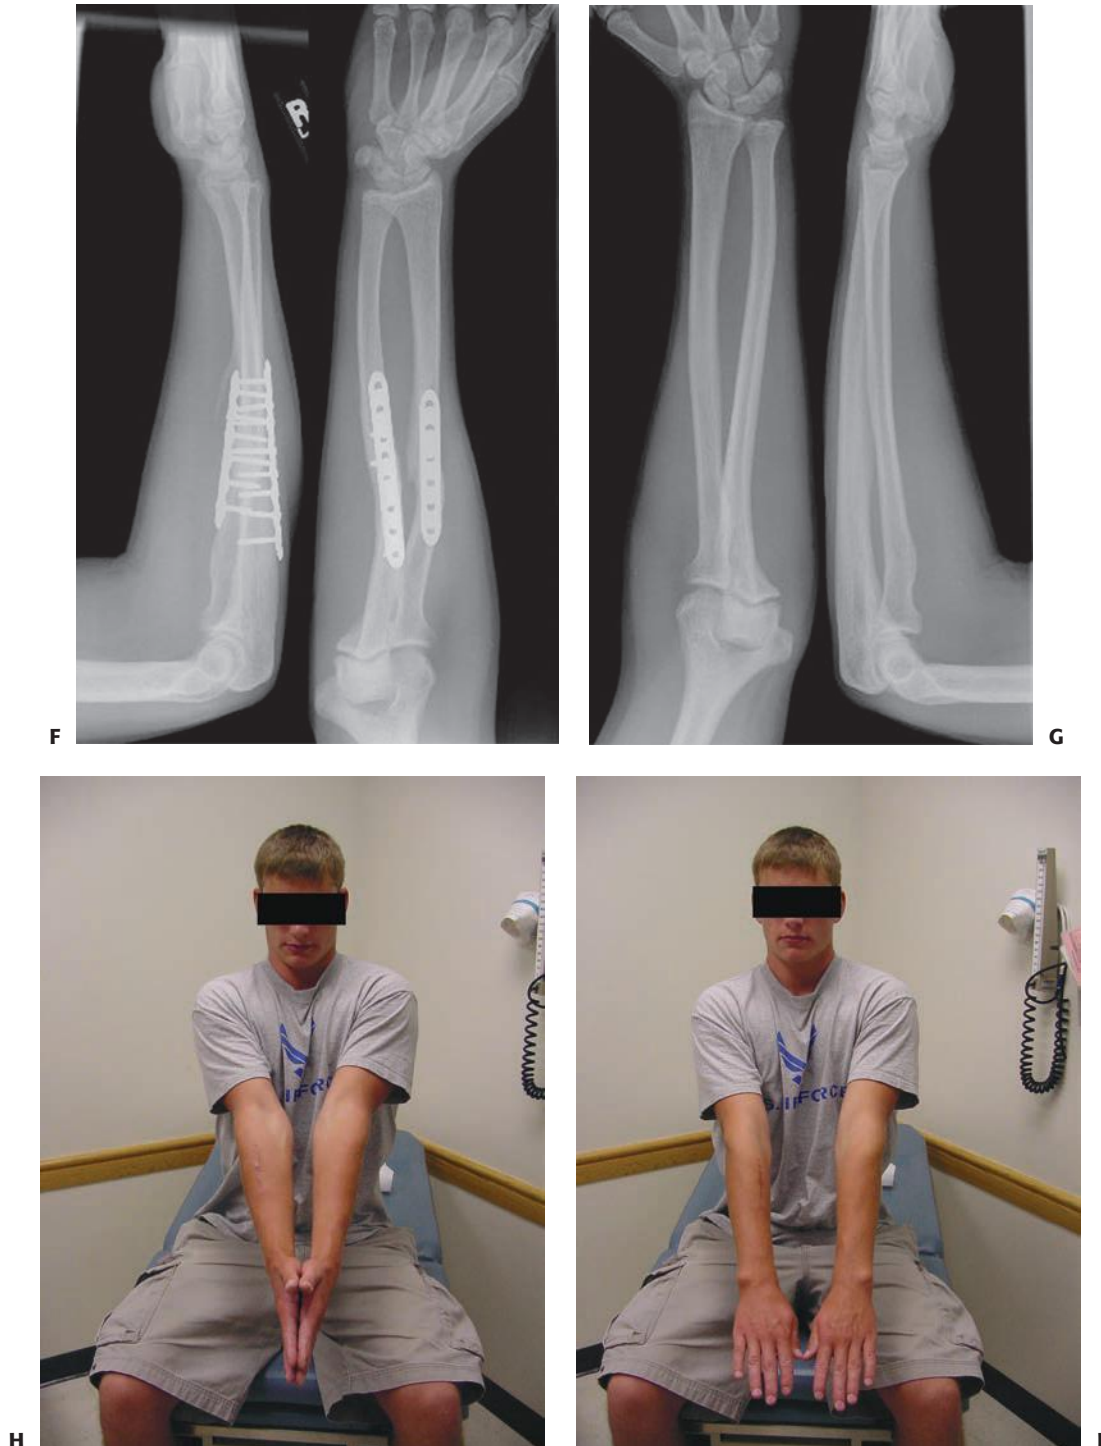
(continued) F: One-year postoperative radiographs following osteotomies. Note improved rotational alignment of radius. G: Uninjured left forearm radiographs. H: Clinical appearance with extended elbows and forearm midposition. I: Clinical appearance with extended elbows and pronated forearms.
